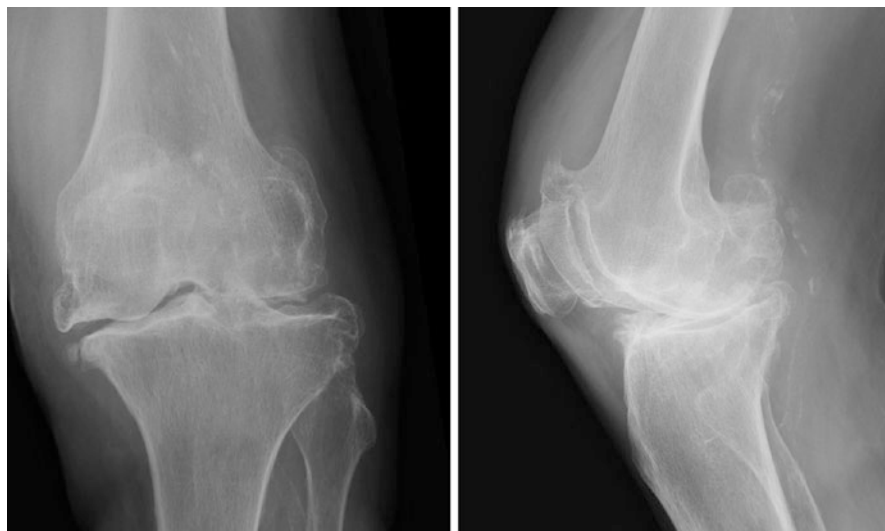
AP and lateral radiographs of the knee of a 69 years old female demonstrating advanced osteoarthritis with diffuse joint space narrowing, osteophytes, subchondral sclerosis and mild subluxation
